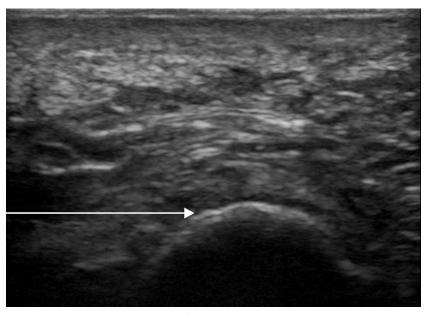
Sonographically guided plantar fascia injection. Arrow denotes needle path. Needle tip placed just deep to plantar fascia just distal to medial calcaneal tubercle. Left, medial; right, lateral.
